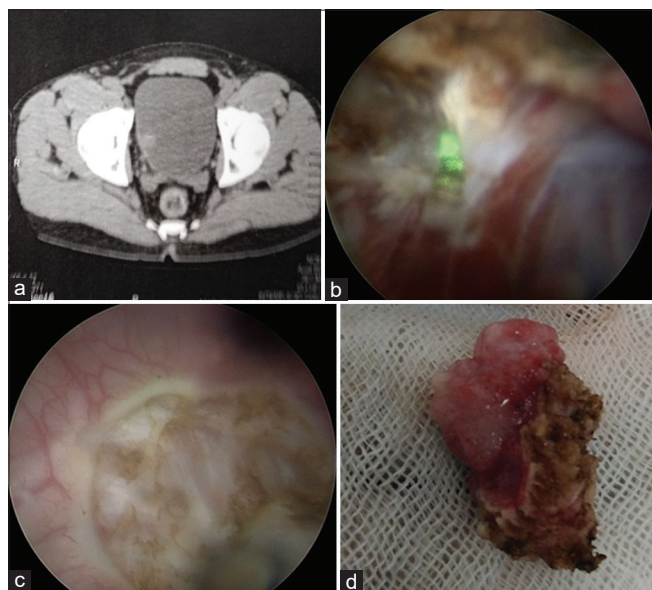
(a) Narrow-based tumor on CT. (b) Laser fiber cutting through muscle fibers. (c) Tumor bed after *en bloc* resection. (d) *En bloc* resected bladder tumor
